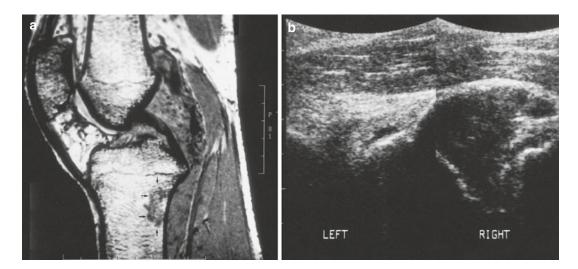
(a, b) Bifocal pigmented villonodular synovitis of the right knee. (a) Sagittal gradient-echo MR image. (b) Longitudinal US image; split screen comparison view of dorsal femorotibial joint space. Marked distention of posterior femorotibial joint space, filled with soft tissue mass of intermediate signal intensity. (a) Multiple foci of low signal intensity are present both in the deep and superficial dorsal aspect of the mass. Intraosseous tumor
